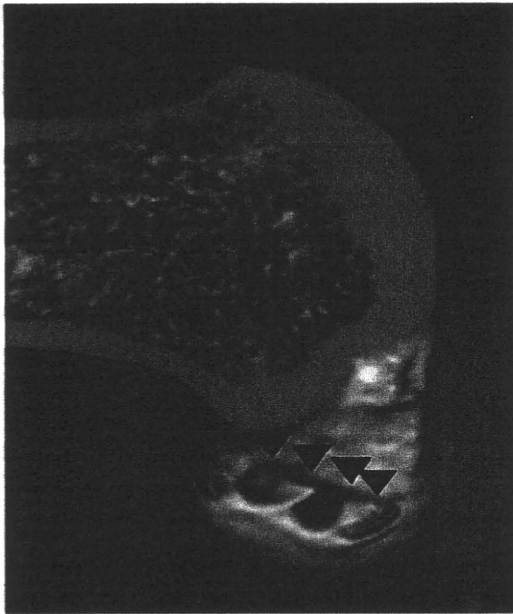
The 2 femoral sockets were prepared anatomically just posterior to and below the lateral intercondylar ridge (triangles) with the knee in 90° of flexion on the 3-D CT scan image
